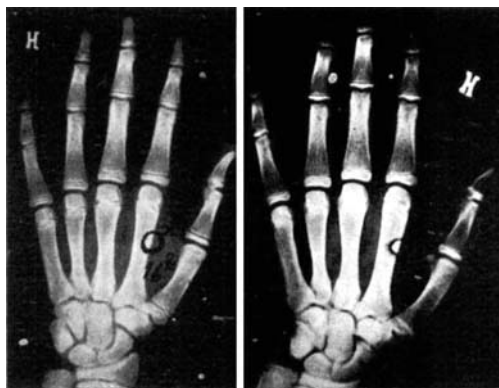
X-rays of the hand and wrist of a boy aged 16² years in whom the skeletal development is delayed by 3 years. At the age of 17¹¹ years the skeletal development is still 2⁷ years delayed, being now 15⁴ years (closure of the epiphyseal plates in most distal phalanges). Slipping of the upper femoral epiphysis was diagnosed at the age of 16⁰ years (Case 67).
